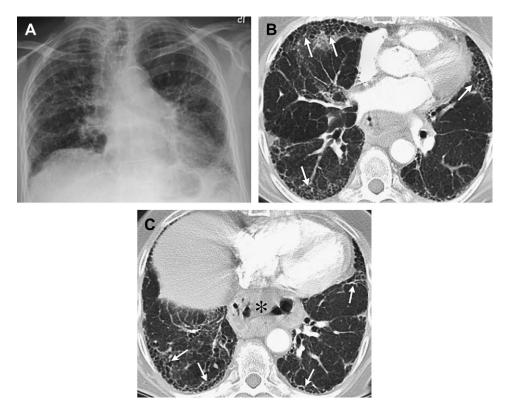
A 73-year-old woman with a radiographic pattern of RA and UIP. Frontal chest radiograph (*A*) shows reduced lung volumes with lower lobe–predominant coarse interstitial markings compatible with pulmonary fibrosis. High-resolution (1.25-mm thick sections) computed tomography (CT) images at the level of the midthorax (*B*) and lower thorax (*C*) show peripheral reticular markings with architectural distortion and small subpleural cysts/honeycombing (*arrows*). The patient also has a large hiatal hernia (*asterisk*).
